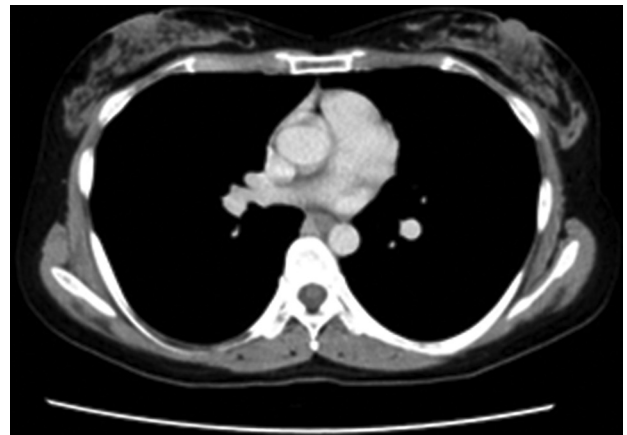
Computed tomography result (contrast computed tomography)
